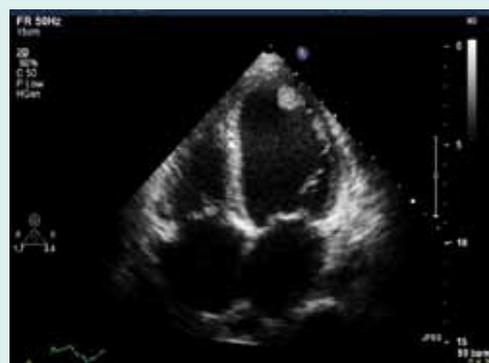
Echocardiogram of a dilated heart and a clot in the left heart chamber
